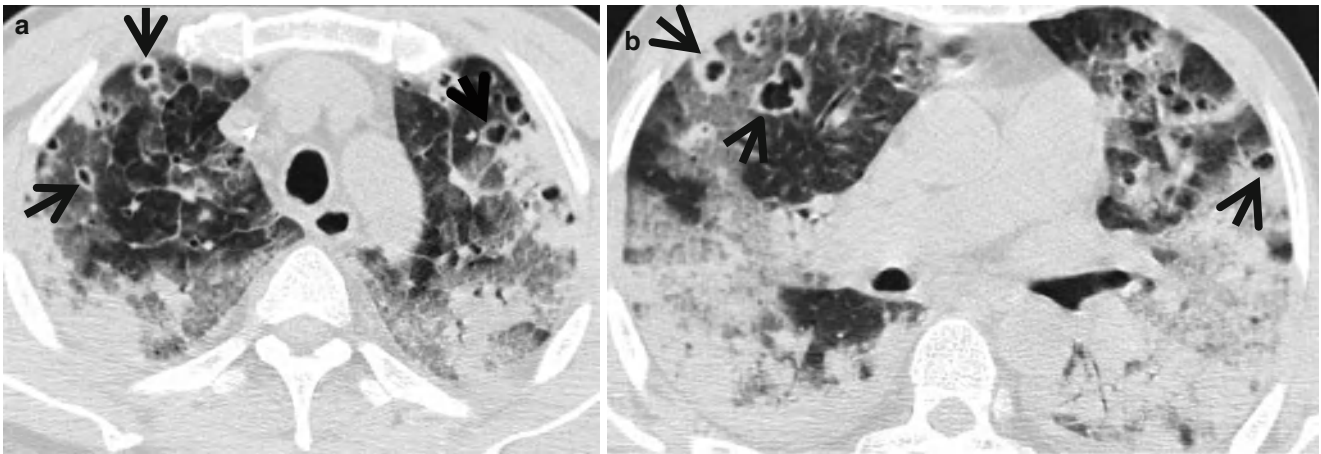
Septic lung in a 58-year-old man with methicillin-sensitive *Staphylococcus aureus* who has a history of electric burn on his left thigh. (a, b) Lung window images of CT (2.5-mm section thickness) scans obtained at levels of aortic arch (a) and right bronchus intermedius
